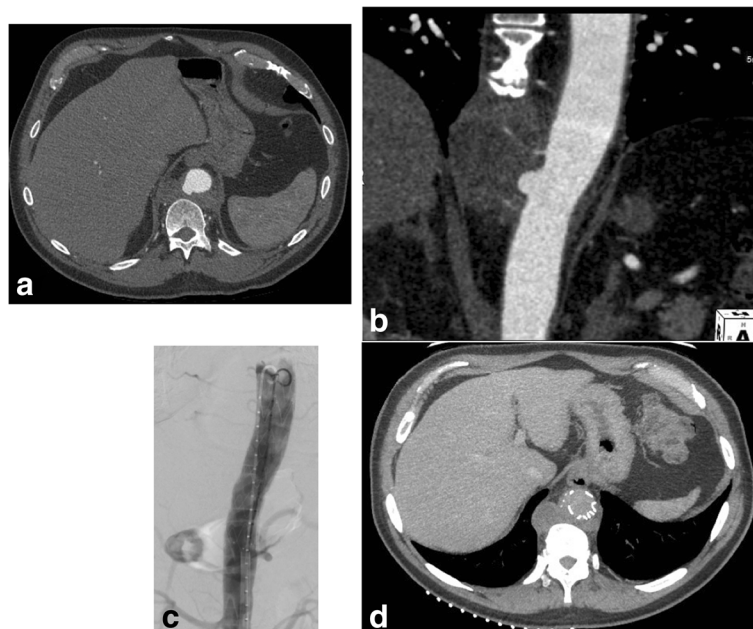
Sixty seven year old male with mycotic aneurysm of the thoracic aorta. a Axial and b coronal images show enhancing, multiseptated, and lobulated low density mass within the lower retrocrural space/posterior mediastinum that abuts the adjacent thoracic aorta along 180 degrees of contact. Focal outpouching of the descending thoracic aorta at this site is consistent with a pseudoaneurysm. c Post stent graft deployment angiogram and d CT show satisfactory placement of the stent graft with no residual pseudoaneurysm or post procedural endoleaks
